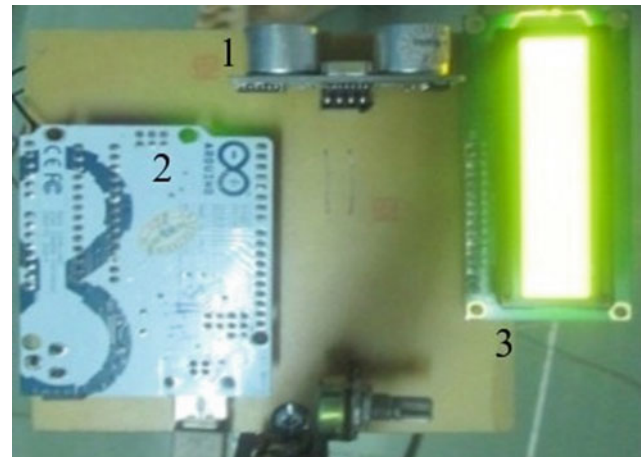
The implemented board for the measurements with 1—the ultrasonic sensor, 2—the Arduino Uno R3 and 3—the LCD screen
